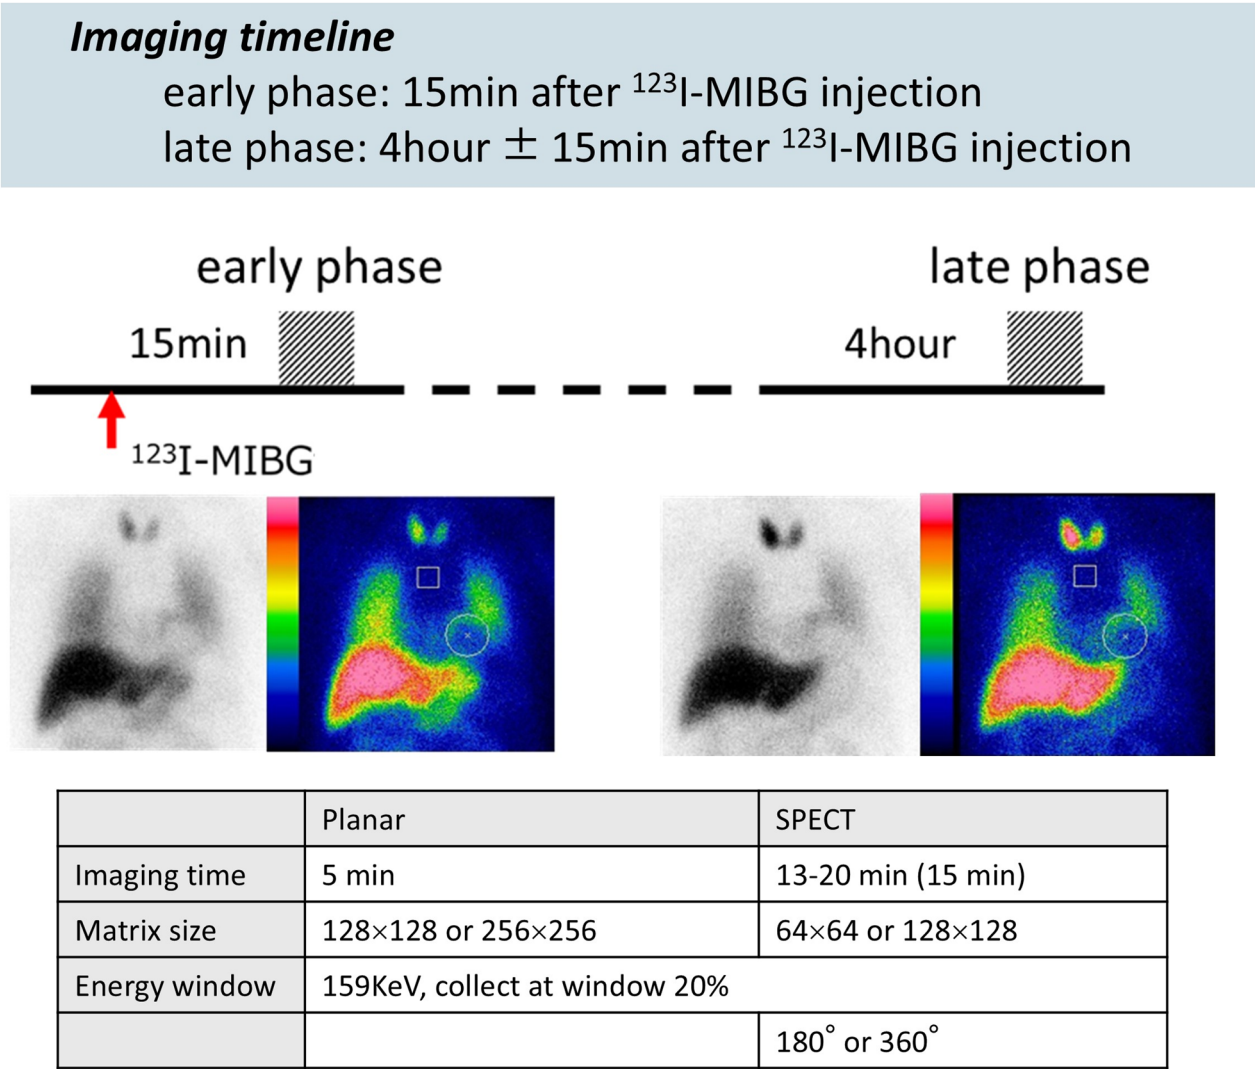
Imaging protocol for I-123 MIBG scintigraphy. Planar and SPECT images are acquired at 15 min (early phase) and 4 h ± 15 min (late phase) after I-123 MIBG injection. Imaging parameters and regions of interest for calculating heart-to-mediastinum ratio and washout rate are shown. SPECT, single photon emission computed tomography; MIBG, metaiodobenzylguanidine
